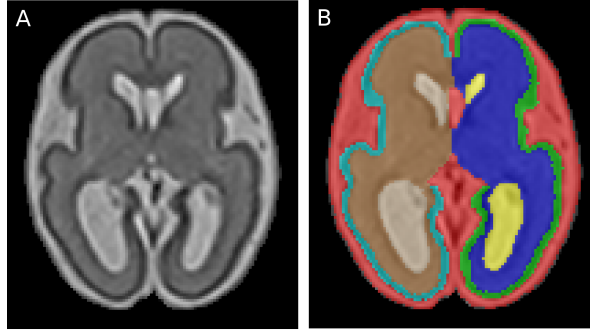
Fetal brain MRI segmentation: 26.4 GW-old fetus with right INSVM (A) and corresponding segmentation (B), with different labels for left and right WM, cortex and lateral ventricles.
